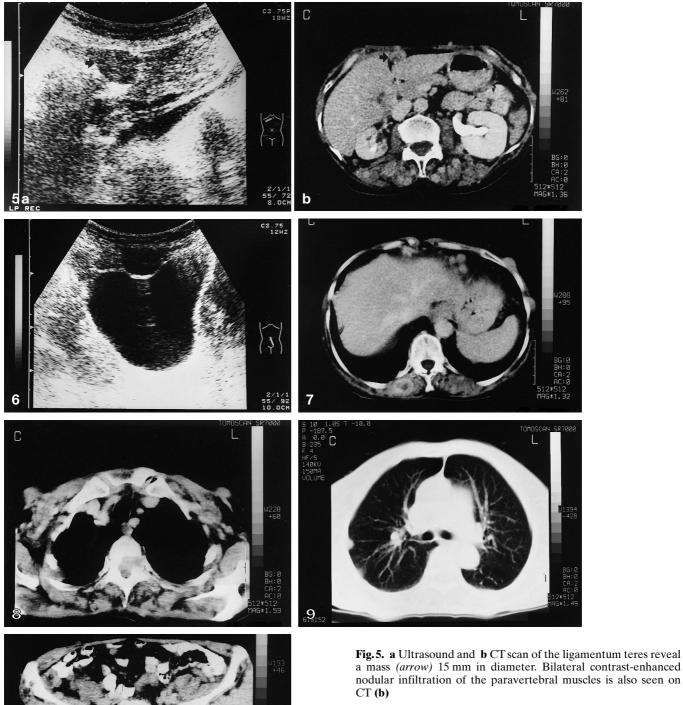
Ultrasound of the urinary bladder shows a hypoechogenic mass, 1–2 cm in size, indenting the anterior wall of the bladder
